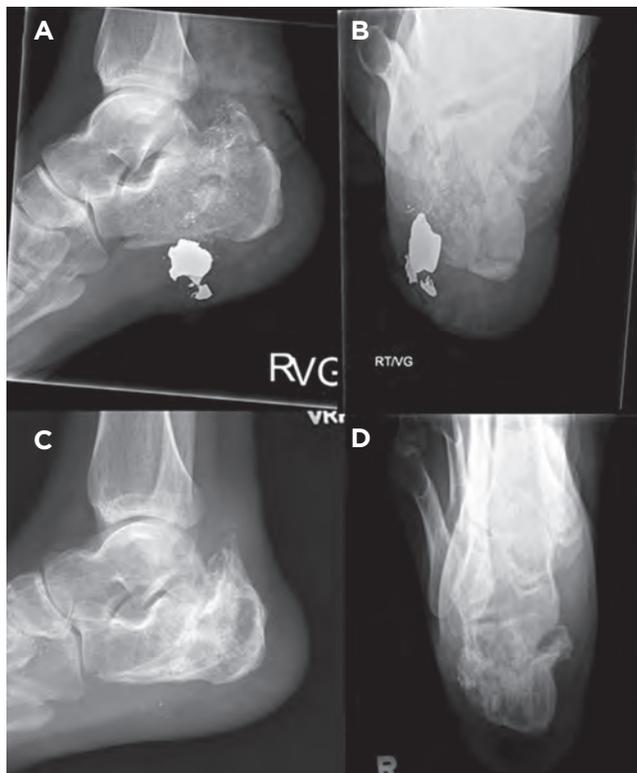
A and C) Lateral and B and D) Harris/axial radiographic views of zone three calcaneus fracture gunshot injury. C and D) represent radiographs at 6-months follow-up. The bullet fragment had been removed.
